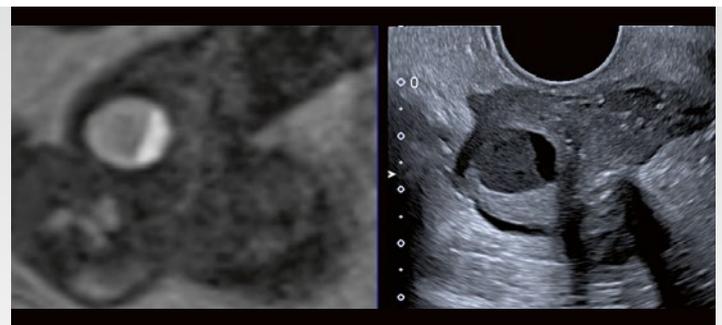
Endometriosis nodule on the right uterine horn on MRI and ultrasound.
